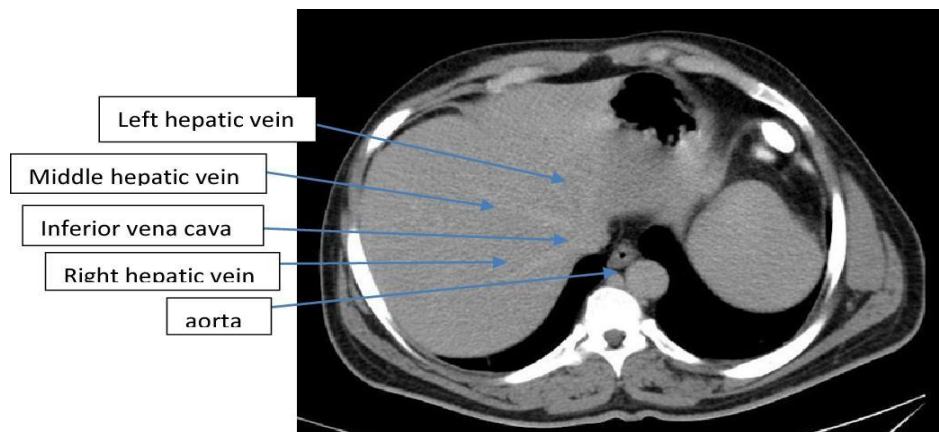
This is a normal CT appearance of the liver in an axial NCCT image, useful for inspecting important anatomic structures such as the left, middle, and right hepatic veins, the inferior vena cava, and the aorta
